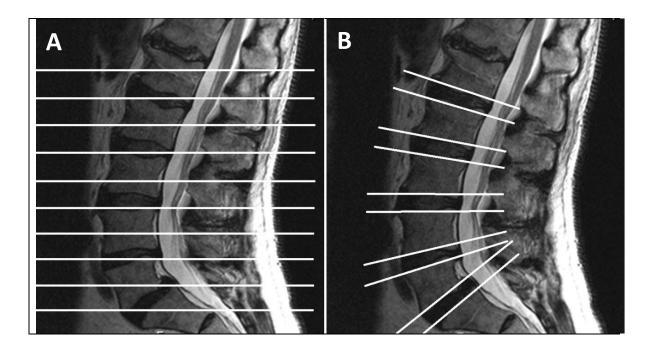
T2-weighted 2D-FSE mid-sagittal MRI depicting different axial imaging slices (white lines) in the lumbar spine. A) "stack" sequence orthogonal to axial plan of the patient. Natural lordosis of spine lead to oblique slices of the lumbar anatomy. B) "through disc" sequence orthogonal to disc spaces. A technician manually defines multiple planes, resetting the axial angle at each disc space level. Interdisc-spaces are not imaged, leading to the potential of missing anatomy of clinical interest.
